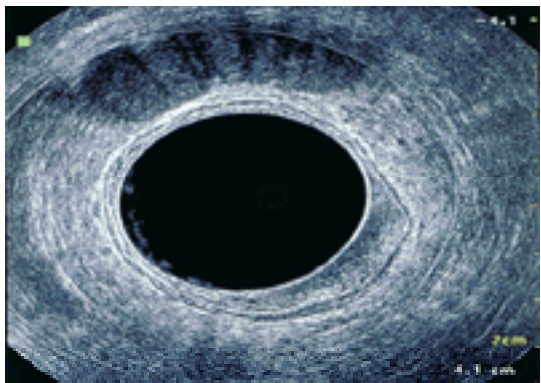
Endorectal ultrasound of an early cancer limited to the submucosa (T1).
